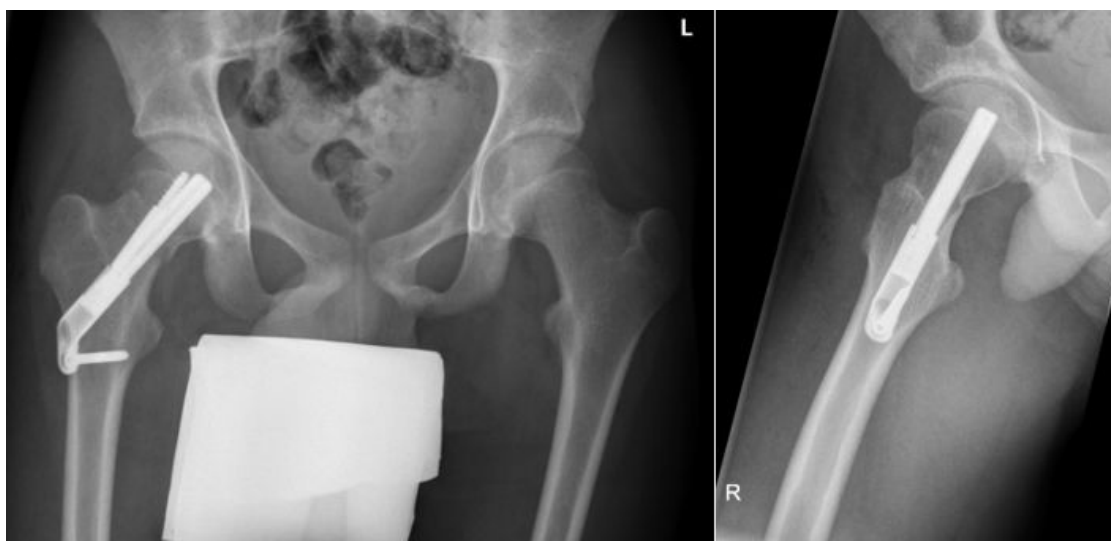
Postoperative radiographs in two planes showing adequate reduction and fixation with the FNS with a one-hole side-plate.
